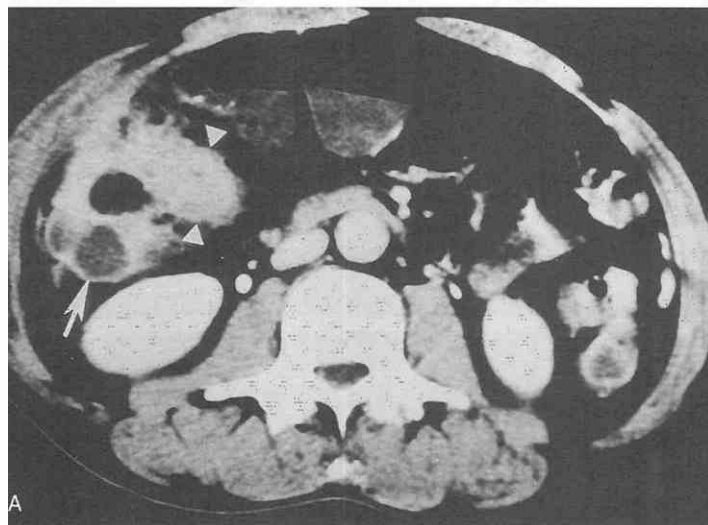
Perforated tuberculous colitis. A, CT scan shows mass-like bowel wall thickening (arrowheads) with colonic obstruction. Ill-defined soft tissue-attenuated lesion is seen in the pericolonic space. There is also evidence of loculated fluid collection (arrow). B, Barium study shows nearly complete colonic obstruction at the hepatic flexure of the colon.
